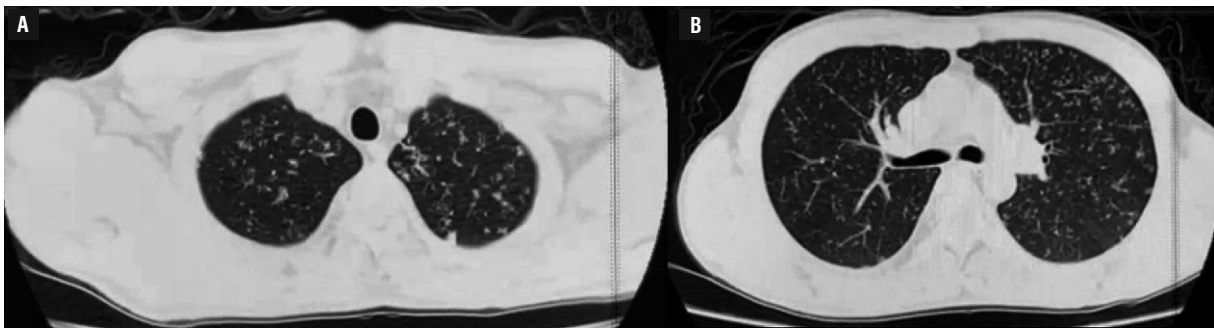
Chest computed tomography performed after one month of treatment. Pictures A and B showing sections equivalent to Figure 1, where improvement of the lesions is observed
